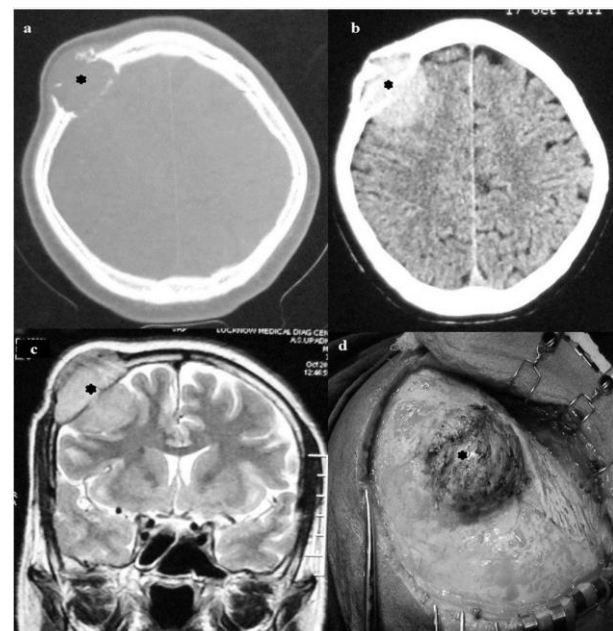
(a) axial image of NCCT Brain in bone window and (b) soft tissue window shows right-sided frontal intra-diploic expansile lesion (*) with intra and extra cranial components causing destruction of both inner and outer tables. MRI brain shows large intra-diploic expansile lesion (c) T2WI of MRI brain in coronal plane shows hyper-intense lesion causing compression of underlying brain. (d) Per- operative image showing extra- calvarial component of the lesion.
